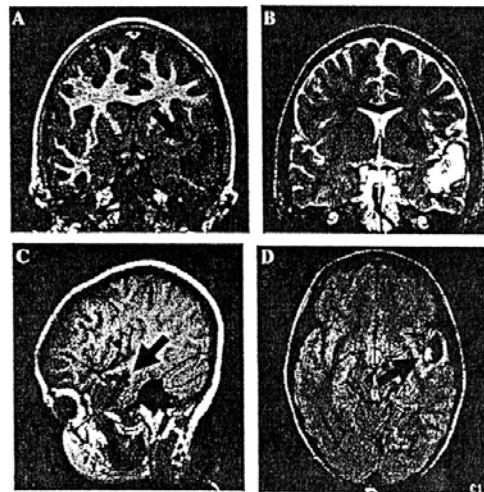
Patient 2. (A) Coronal T1-IR image, (B) coronal T2 image, (C) sagittal T1 image, and (D) axial FLAIR image showing the left temporal lobe lesion (arrows).
